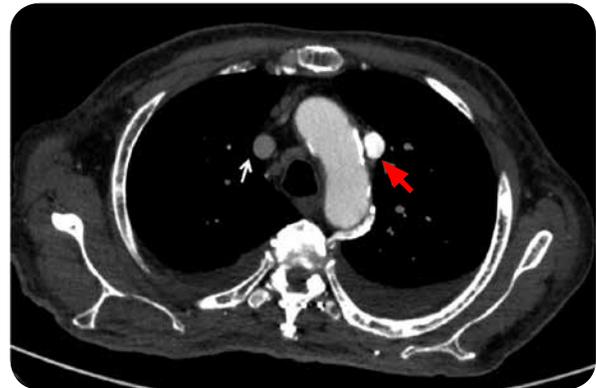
Angio CT, axial section. At the level of the aortic arch there are two vascular structures: right superior vena cava (white arrow) and left superior vena cava (red arrow) and bilateral pleural effusion.
